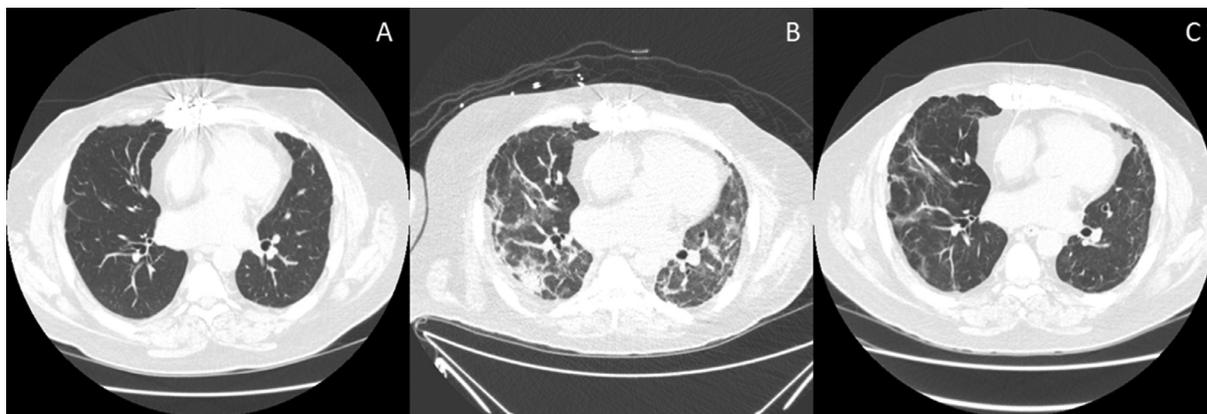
Serial CT chest images of 55/M liver-lung transplant patient with COVID-19. First image is from 1 month before the infection (A). He presented acutely ill with refractory hypoxemia and multiorgan dysfunction requiring mechanical ventilation, paralytics, inhaled nitric oxide and prone positioning. The second image shows parenchymal opacities during the active infection (B). He was treated with supportive care, corticosteroids taper, antibiotics and two doses of tocilizumab. He slowly improved and after a prolonged hospital stay, he was weaned off oxygen. His CT chest 6 months after infection showed bilateral reticular opacities (C) while spirometry showed an FEV1 loss of 15% from pre-infection baseline.
